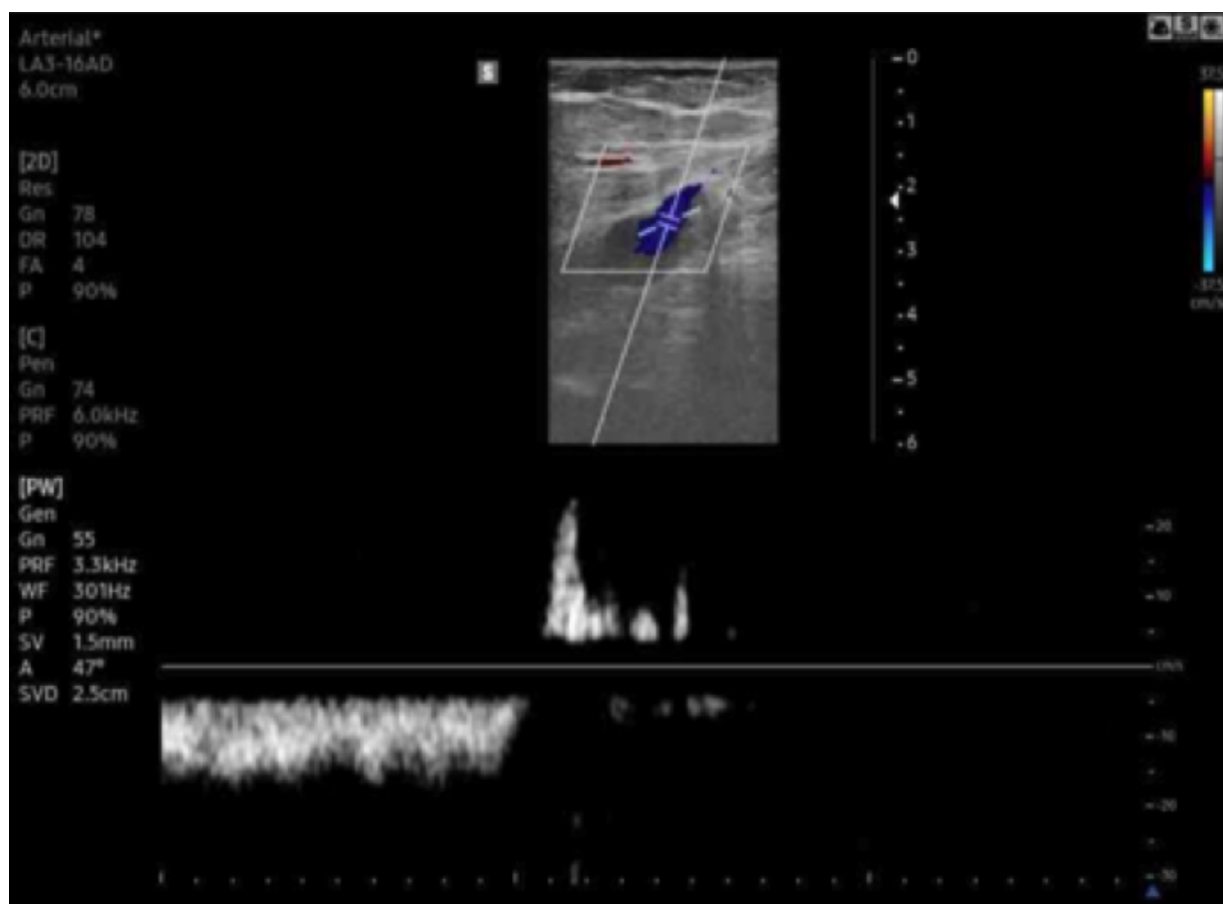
Reflux flow in lower extremity venous on Doppler ultrasonography.
